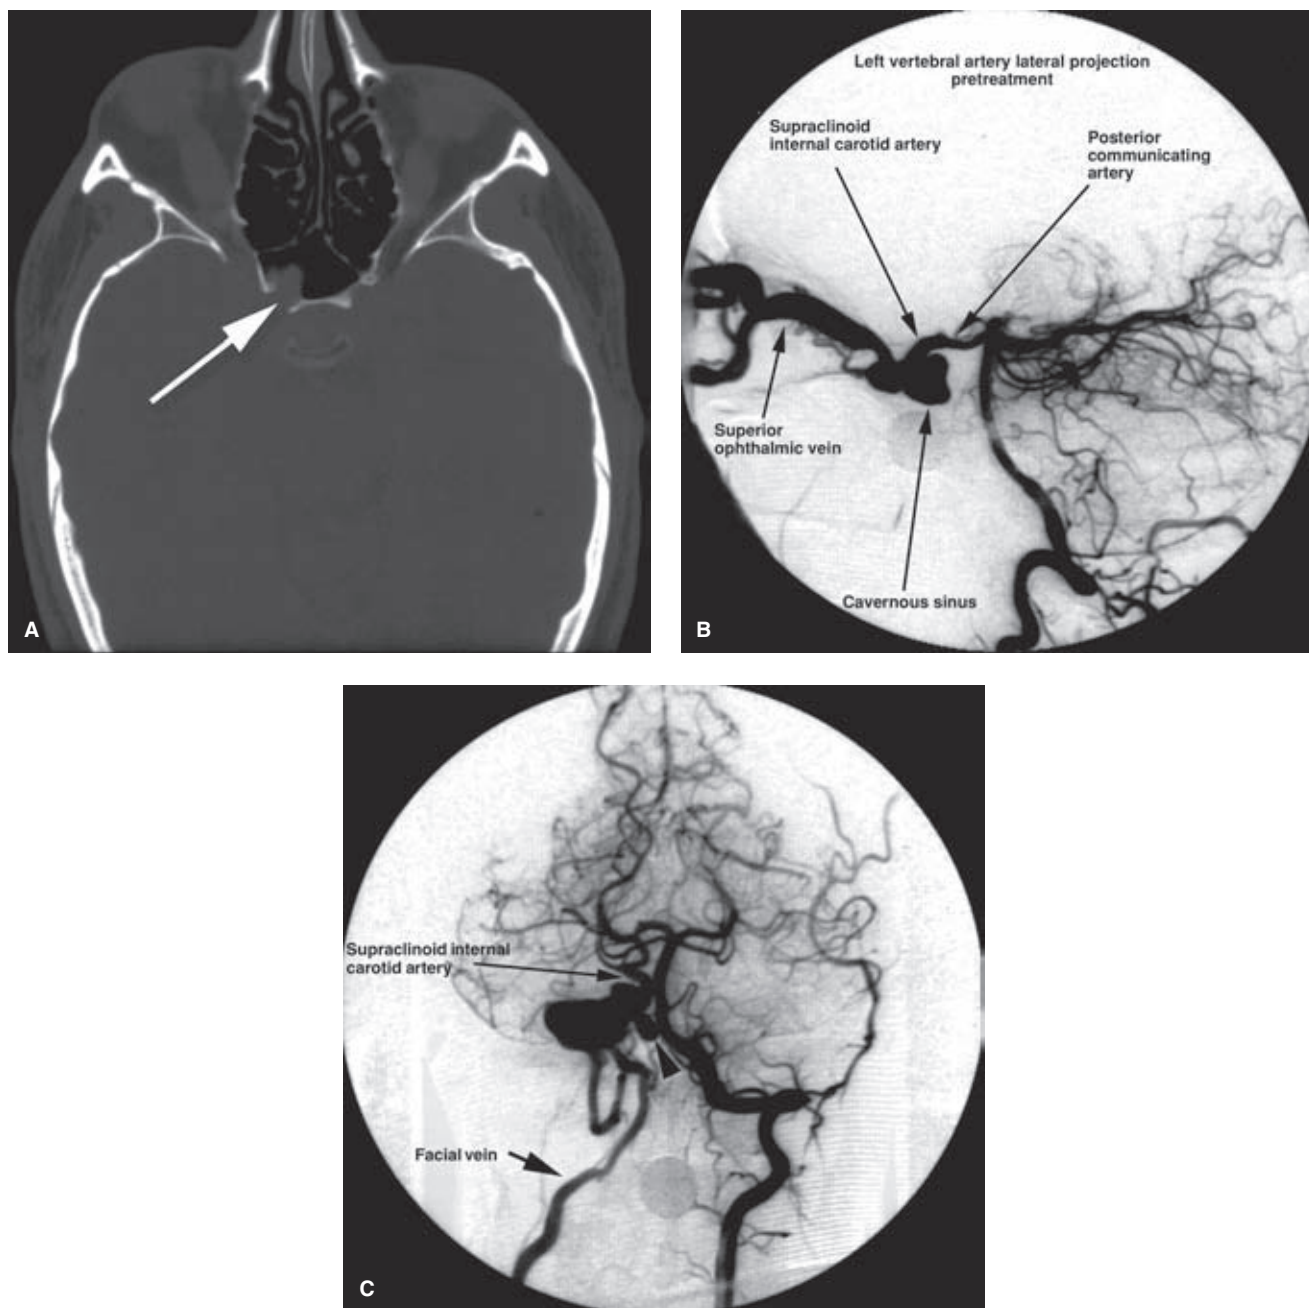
(A–C) Posttraumatic carotid-cavernous fistula with ipsilateral carotid dissection. A young adult male presented with history of mild right-sided proptosis and a pulsatile bruit following an assault with a lead pipe. A CT examination demonstrated prominent vascular structures in the region of the right cavernous sinus. A most significant finding on the bone windows was a breach (*arrow* in A) in the bony wall of the sphenoid sinus with protrusion of a soft tissue density from the cavernous sinus. With a history of trauma and a diagnosis of carotid-cavernous fistula, the possibility of a pseudoaneurysm or tense venous pouch expanding into the sphenoid sinus must be considered, raising the risk of life-threatening epistaxis from that site. The right common carotid artery arteriogram (not shown) demonstrated complete occlusion of the right internal carotid artery. The carotid-cavernous fistula filled via the right posterior communicating artery from the left vertebral artery injection (B). Contrast flows from the right posterior cerebral artery to the supraclinoid internal carotid artery. A distended cavernous sinus drains exclusively to a massively distended superior ophthalmic vein. Despite the torrential rate of flow in the superior ophthalmic vein, the patient's proptosis was mild. This was because of prompt drainage to the facial vein, seen on the Townes view (C). On this view, a medially projecting pouch (*arrowhead* in C) from the genu of the internal carotid artery is seen, correlating with the CT appearance in (A). Because of the possibility of massive epistaxis from the pouch or pseudoaneurysm, urgent embolization was undertaken.
